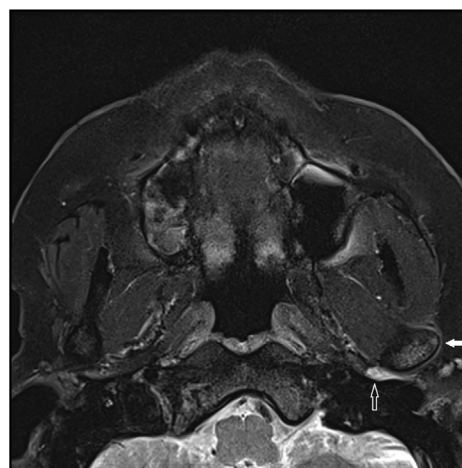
Magnetic resonance imaging of the left temporomandibular joint prior to risankizumab therapy, indicating areas of hyperintensity and inflammation (black arrow) with associated bone marrow edema (solid white arrow).
